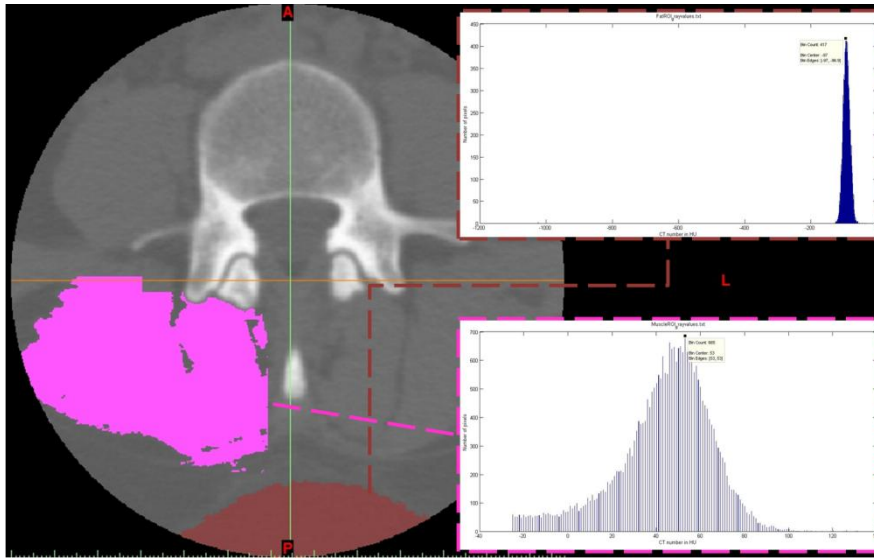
ROI selection for fat (red) and paraspinal muscle (pink) and respective histograms with the most frequent CT value for each.
